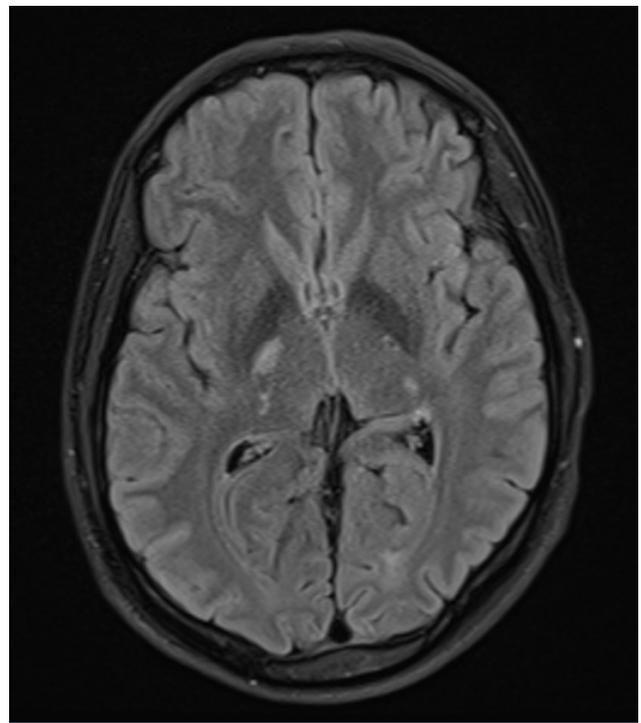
MRI FLAIR image showing multiple old lacunar infarcts
